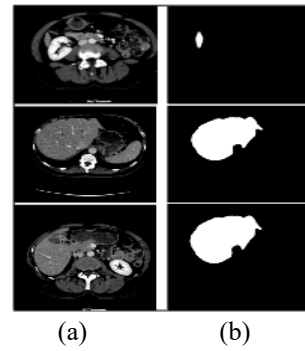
Outcomes of segmentation (a) original CT images (b) segmented region.
